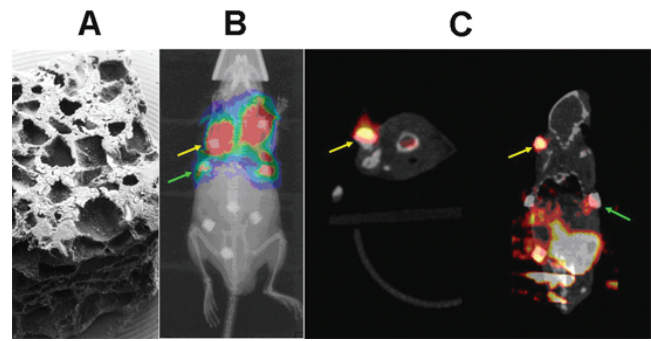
Imaging stem cell implant with NIS gene as the reporter. Overlays of CT and SPECT images with the arrows pointing to the upper left cube (A), which is loaded with NIS-transduced MSCs; to the s.c. injection site (B) with the same NIS-transduced MSCs. The thyroid/salivary glands and the stomach (gastric mucosa) have high uptake in both (A) and (B) due to endogenous NIS expression.
